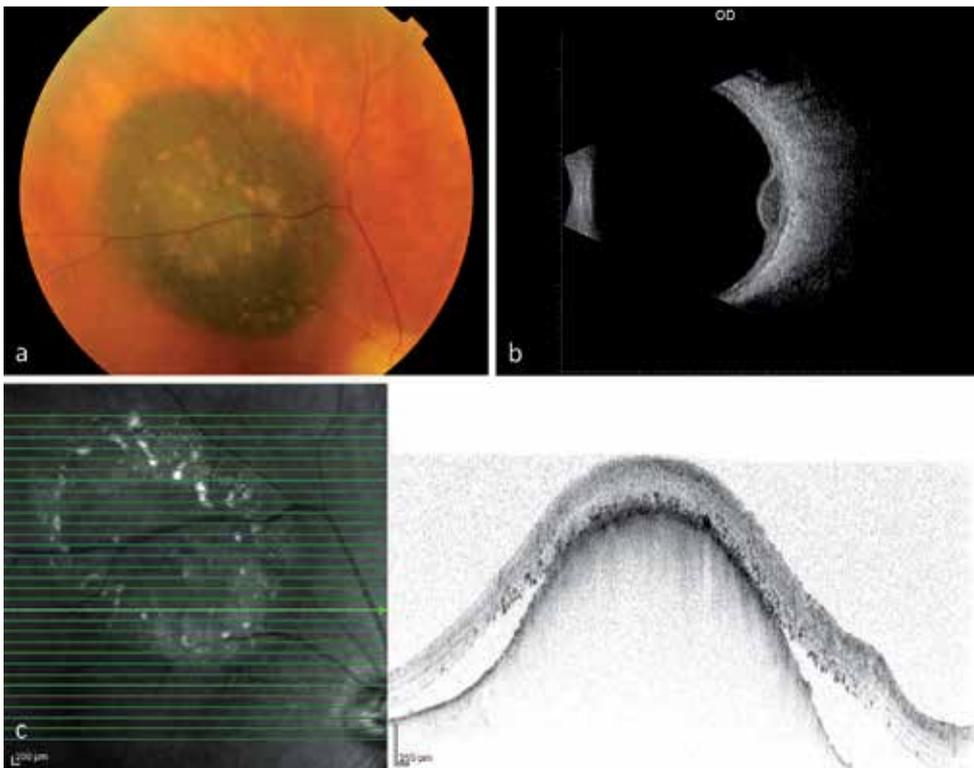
a: A dark pigmented uveal melanoma with orange pigment; 2b: On B-scan ultrasonography acoustic hollowing and choroidal excavation is present, 2c: Subretinal fluid and retinal pigment epithelial alterations are visible on optical coherence tomography scan at the top of the tumour.
